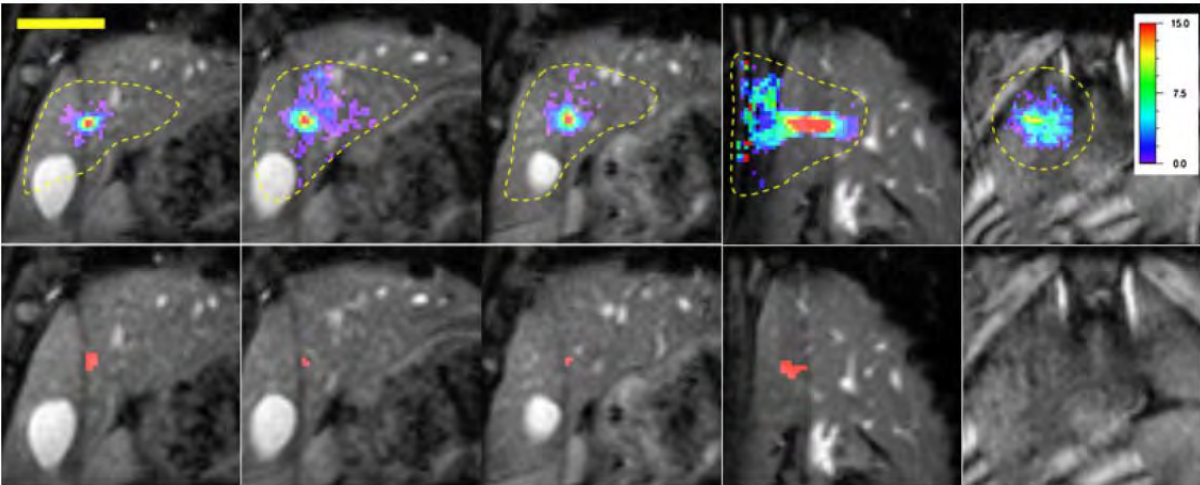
Temperature (top row) and thermal dose (bottom row) images of the liver during HIFU ablation. The region exceeding the 240CEM43 is shown in red in the thermal dose image. MR images are obtained by a single-shot gradient-recalled echo planar imaging (EPI) sequence with multislice acquisition. Reproduced from (Quesson et al., 2011).
